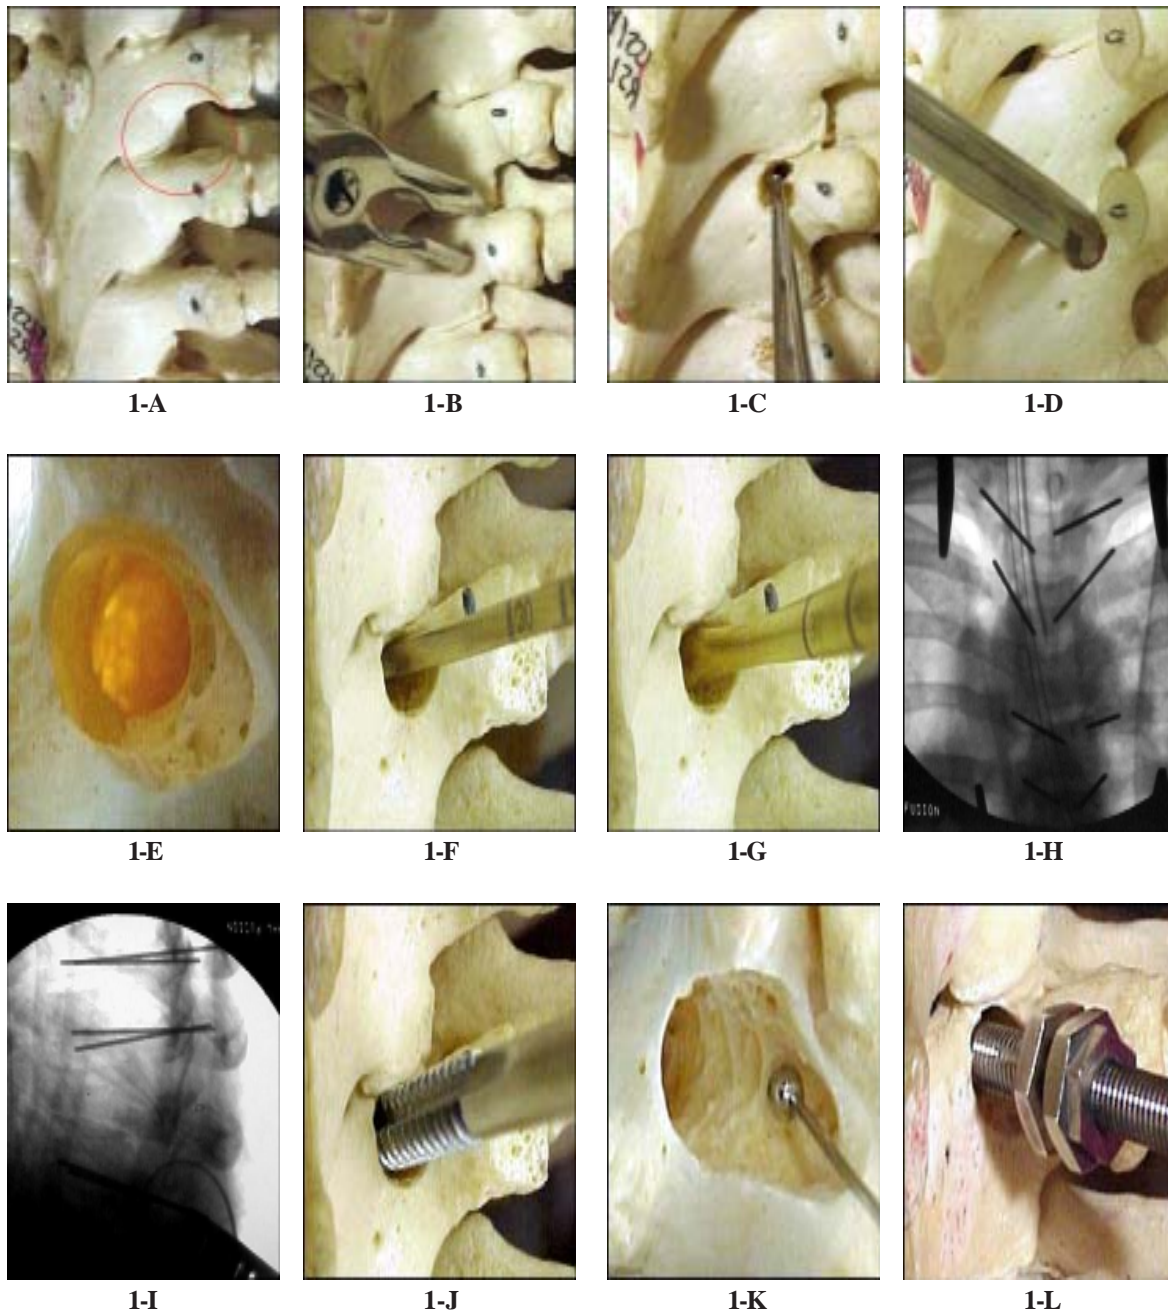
A: The posterior projection of the pedicle was estimated (Just superior to the intersection between the midline of the base of the transverse process and the lateral border of the facet joint). B: The posterior cortex overlying the top of the pedicle was removed by a rongeur. C: We remove the cancellous bone from the upper part of the pedicle with a small curette. D: A Kerrison rongeur was used to enlarge the cortical pedicle opening if necessary. E: The pedicle can be visualized. F: Careful probing of the pedicle isthmus with a 2-mm pediatric pedicle probe. G: If the pedicle inner diameter allowed, probing it with a standard 4- or 5-mm pedicle probe. H and I: A 55-mm-long K-wire was placed as radiographic markers using an image intensifier to confirm their proper placement. J: The pedicle was then tapped with a 5.5 mm tap. K: All pedicles were then evaluated for perforation using a ball-tip probe. L: Placement pedicle screw was introduced
